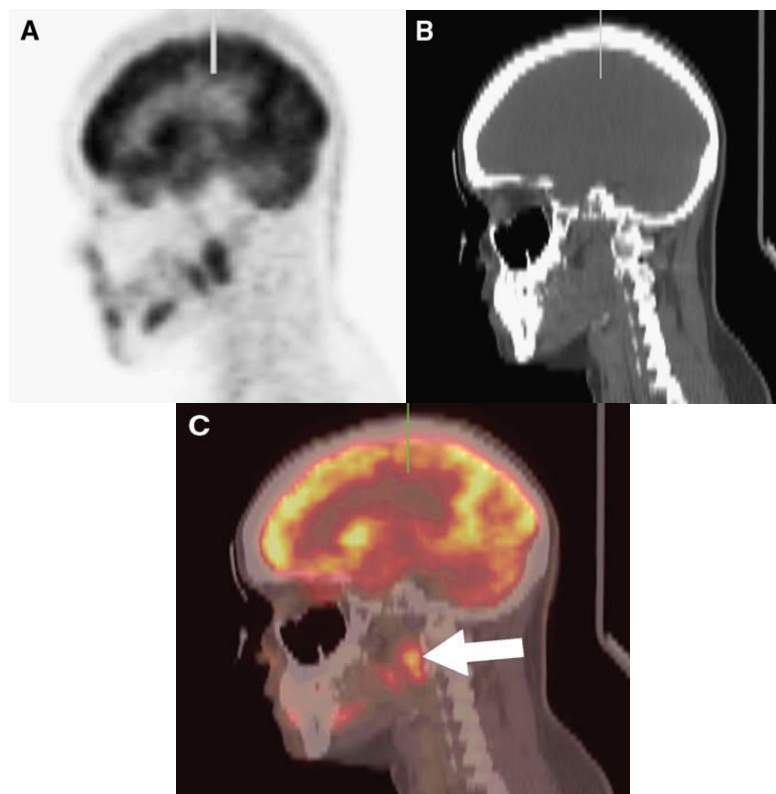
Tumor localization and image alignment with a PET/CT scanner: A and B is the sagittal PET and reformatted CT images of the head. C is the combined PET/CT image showing tumor localization in the right retropharyngeal space (arrow) [26]
